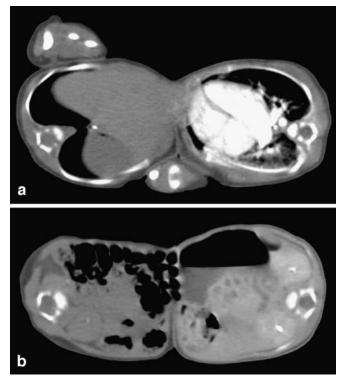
CT. a Contrast-enhanced CT of one twin fused at the thorax shows enhancement only in that twin's heart and aorta indicating separate hearts, i.e. omphalopagus twinning. b Delayed images more inferiorly show four contrast-enhanced kidneys (although only a small amount of contrast medium in the contralateral twin's upper kidney is seen here)
